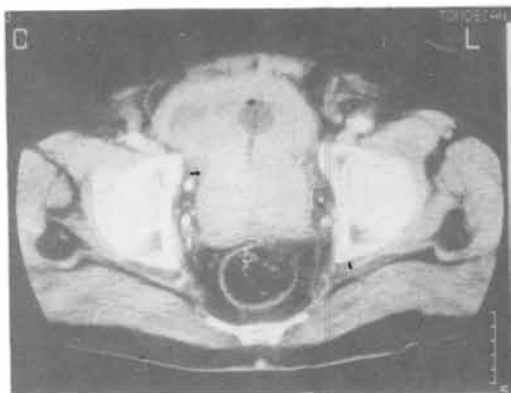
CT scan showing very thick walled bladder and a large middle lobe of the prostate protruding into the bladder.
